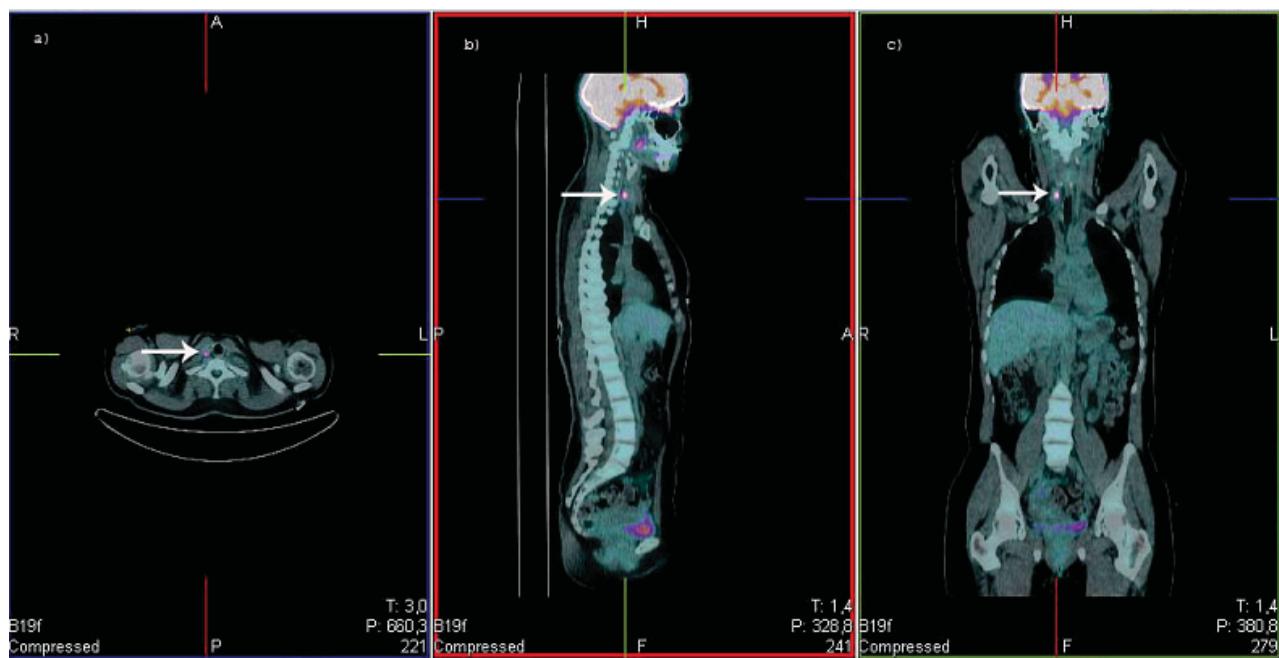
The FDG PET/CT (fluorodeoxy glucose positron emission tomography/computed tomography) of the same patient (Figure 3), demonstrating the hypermetabolic FDG focus localized in jugular lymph node on the right side, is compatible with recurrent disease
